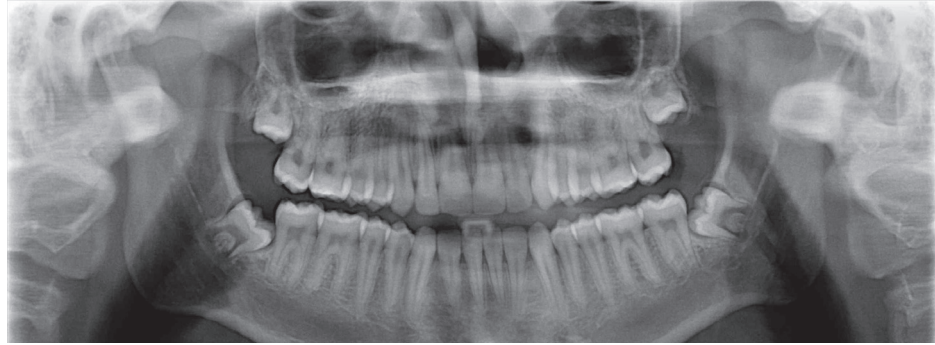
Panoramic radiograph taken when the boy was 17 years old.
